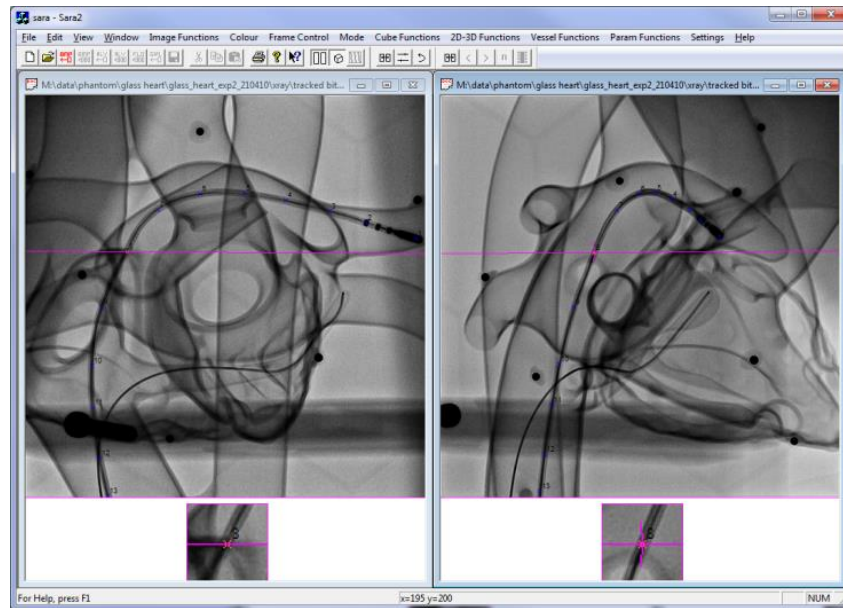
X-ray LAO 30° and PA views with IVC-CS guidewire and IVC-SVC catheters inserted. A point from one view generates an epipolar line (*magenta*) in the other view containing its corresponding point q; their back-projections reconstruct the point in 3D.
